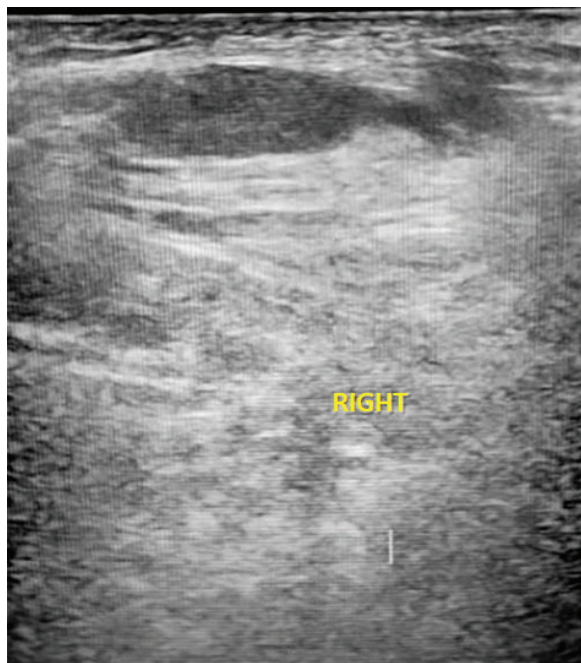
Preoperative ultrasound showing dense echo in the soft tissue of the right palm.
